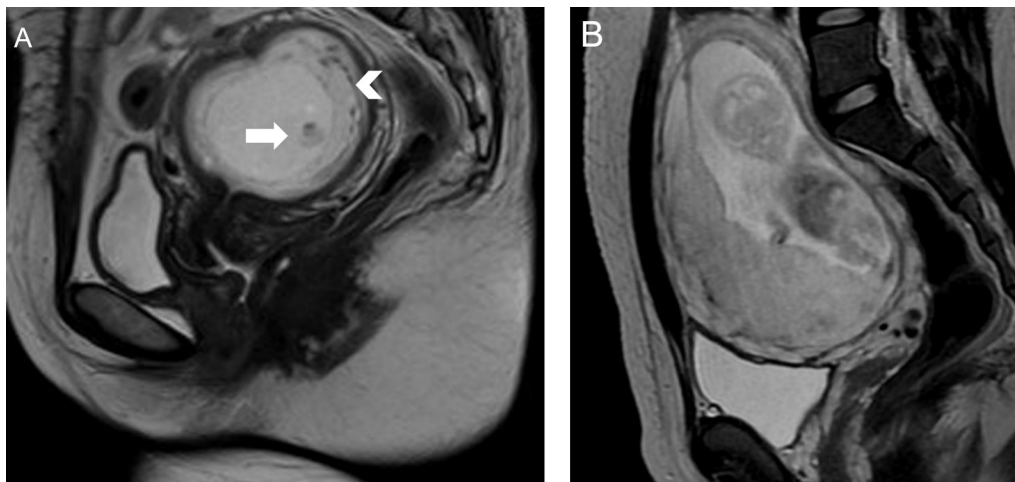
Normal intrauterine pregnancy: A) Sagittal T2-weighted image of intrauterine early pregnancy shows small fetal pole (arrow) with thick curvilinear placenta (arrowhead); B) Sagittal T2-weighted image of intrauterine pregnancy at second trimester shows placenta and fetus.
